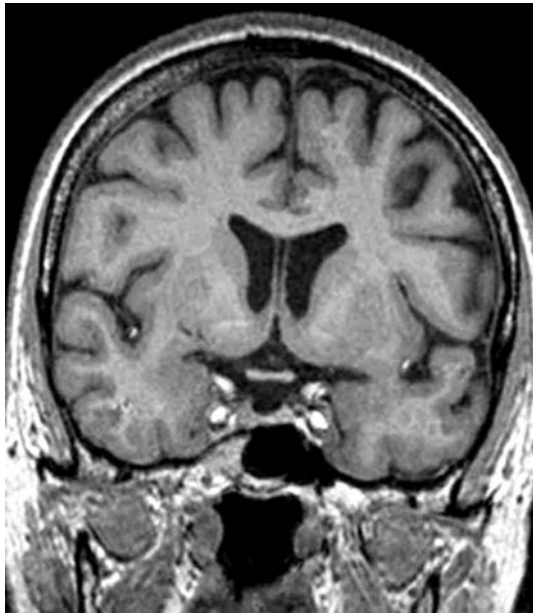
MPRAGE sequence (T1-weighted) in coronal orientation (TR/TE 11.6/4.9 ms; eff. slice thickness: 1.5 mm, 512 x 512). This example shows a thin space between the two leaflets of the SP
